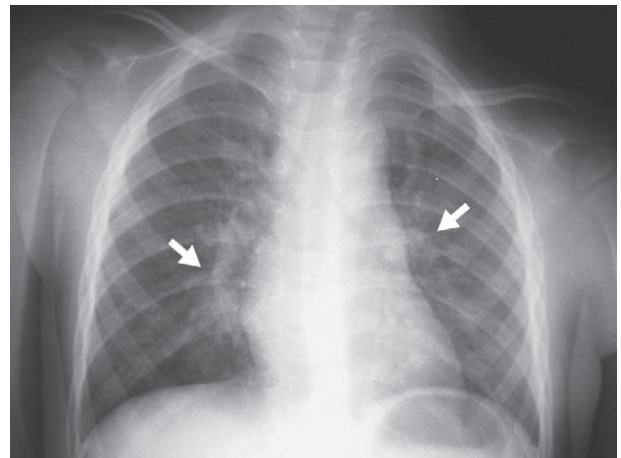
A 2 year-old previous healthy girl presented with an approximately 1 week history of fever and productive cough. Initial chest radiograph shows bilateral peribronchial and perivascular interstitial infiltrates (arrows).
